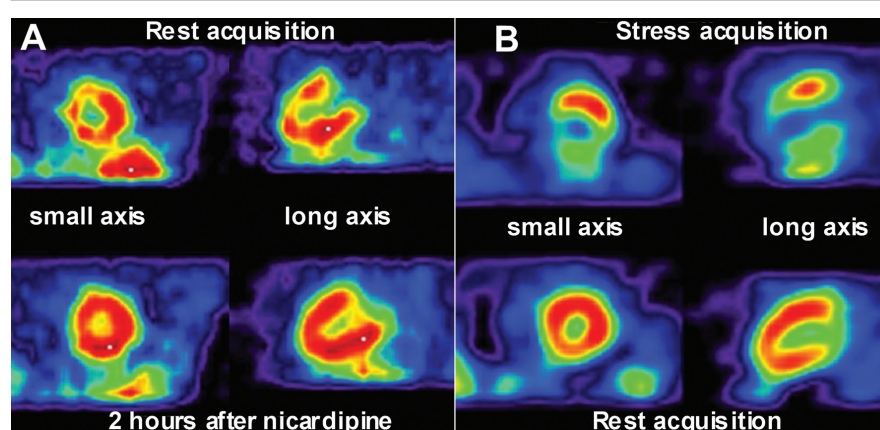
Thallium scintigraphy showing in microvascular *versus* macrovascular disease.
